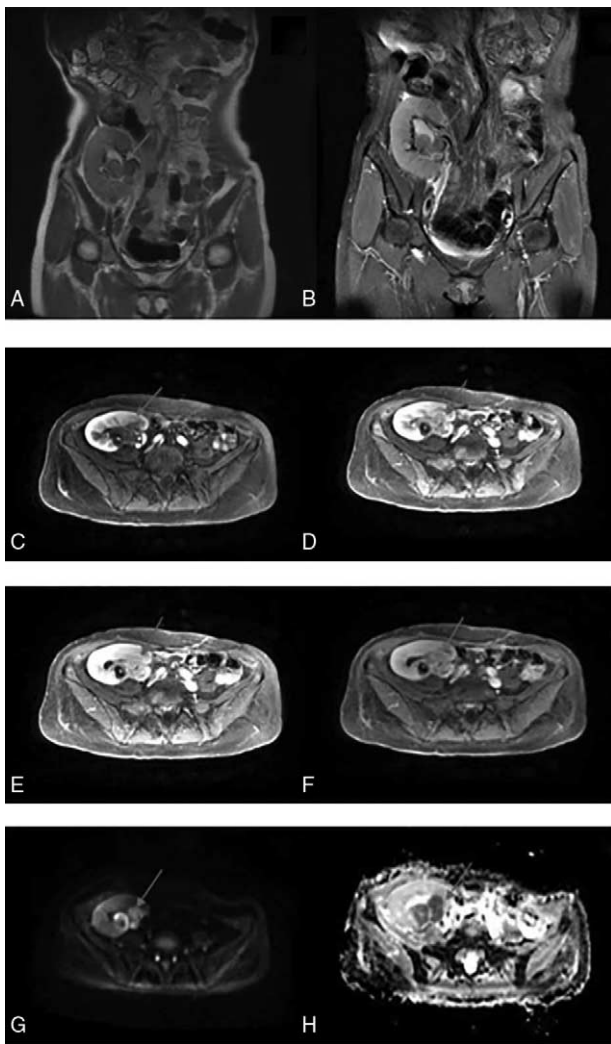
Repeated examination 2 months later. T2-weighted imaging (A)/T2-weighted imaging + fat suppression (B) sequence depicted persistent slight hypointensity, but the lesions were bigger. Dynamic contrast enhancement scanning (C–F) showed persistent peripheral enhancement. The diffusion-weighted imaging sequence (G) and apparent diffusion coefficient value (H) were similar to those of the previous examination. ADC=apparent diffusion coefficient, DWI=diffusion-weighted imaging, T2WI=T2-weighted imaging.
